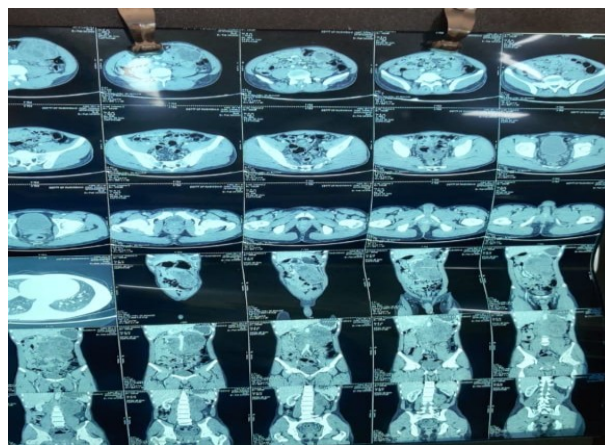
showing CT scan showing the retroperitoneal mass
